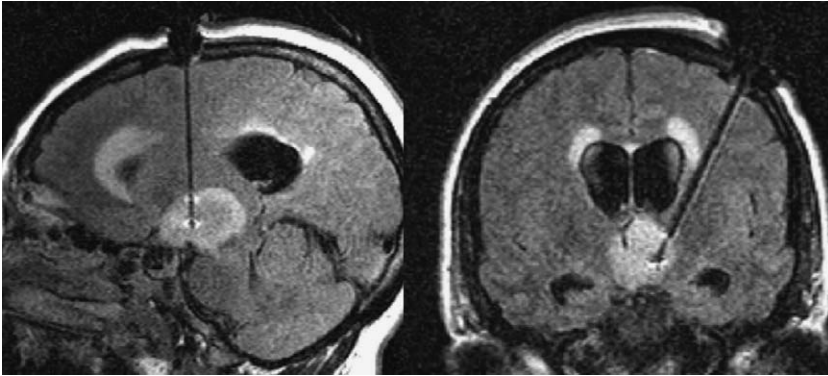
Orthogonal sagittal (left) and coronal (right) turbo fluid-attenuated inversion recovery MRI along the entire length of the titanium brain biopsy needle once it has reached the target in the left thalamus found to be an astrocytoma.
